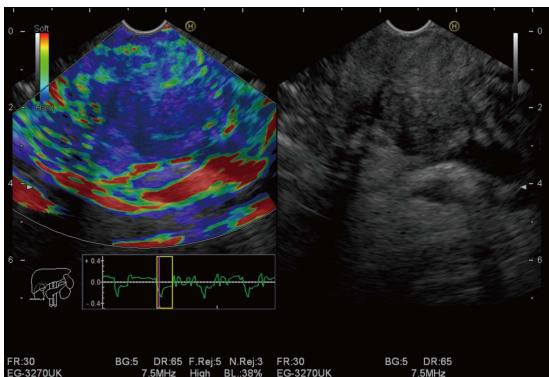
Endoscopic ultrasound elastography of pancreatic adenocarcinoma. The color pattern showed predominant blue color pattern without distortion of surrounding area.
